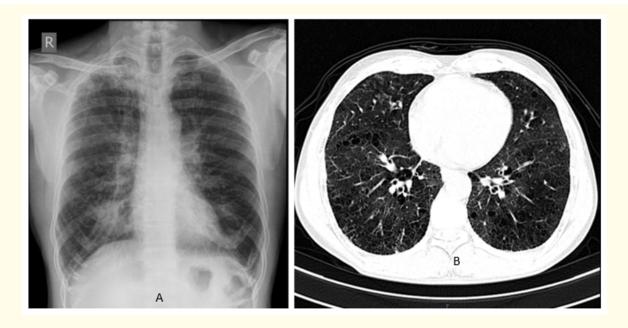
X-Ray Chest PA view showing hyperinflation and bilateral diffuse reticular shadows. 1B: HRCT Thorax axial section from the lower lobes shows extensive reticulation, bronchiolar wall thickening, air trapping and cyst formation.
